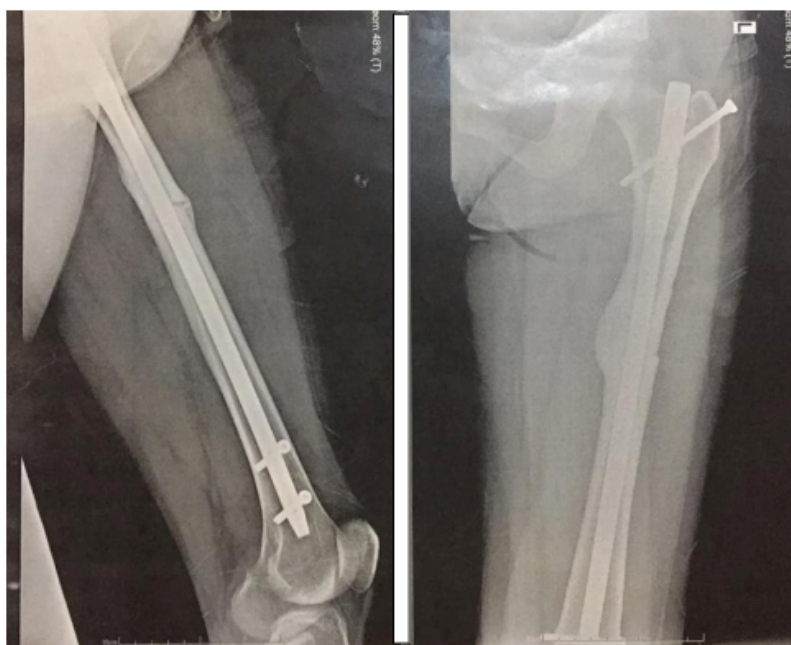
The 10-month post-operative radiograph
